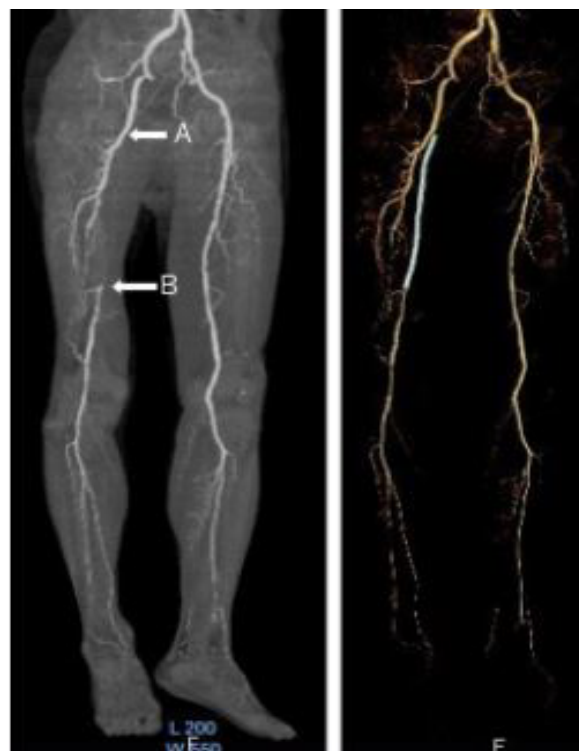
Contrast-enhanced computed tomography. Proximal (A) and Distal (B) edges of the in-stent occlusion.
